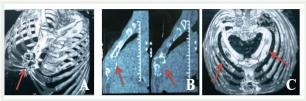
Chest computed tomography scan sequencies: Sternal plasmacytoma (A and B), multiple costal plasmacytomas (C)
